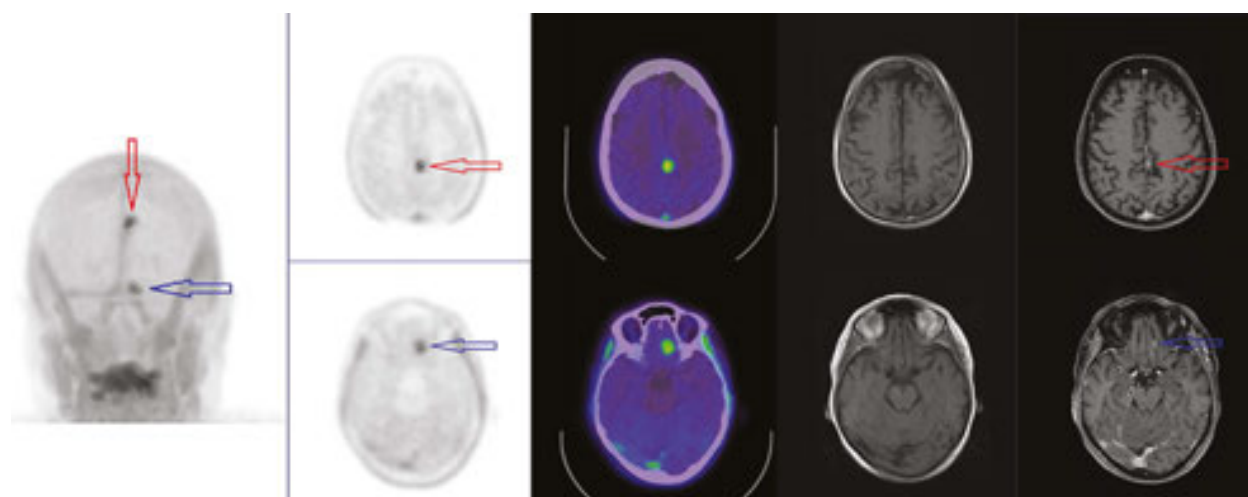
FET PET/CT (left-sided panels) and pre/post intravenous gadolinium MRI (right-sided panels) in a patient with two small cerebral melanoma metastases (red and blue arrows).
